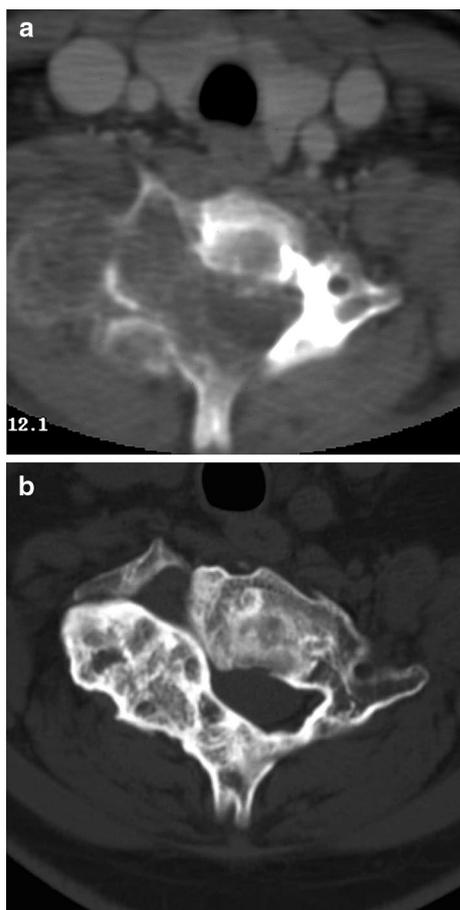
a 14-year-old girl; ABC of C5. Diagnosis achieved by CT-guided trocar biopsy. The amount of the erosion suggests a consistent risk of fracture and she complains of pain and loss of motor function at the right upper limb. After the first SAE, pain started to subside and motor function gradually recovered. b CT scan after seven SEA: the reconstruction is completed and motor function is normal. 7 years of clinical follow-up: no evidence of local recurrence
